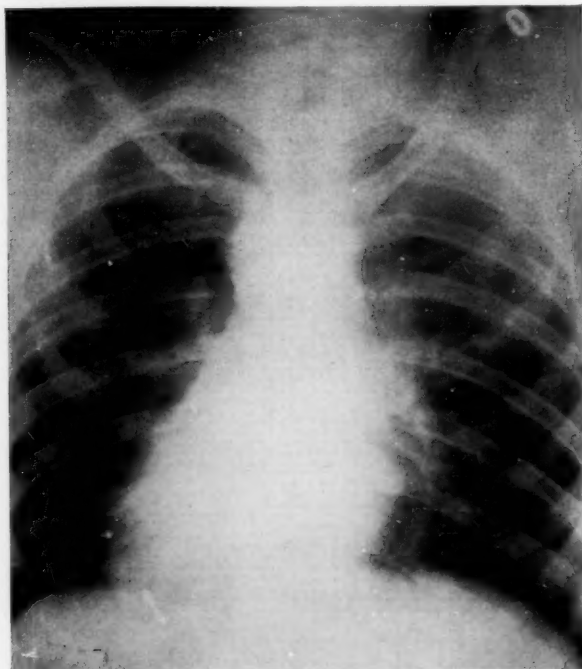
X-ray plate of chest in Case II on fortieth day. The cardiac shadow is slightly larger than normal.
